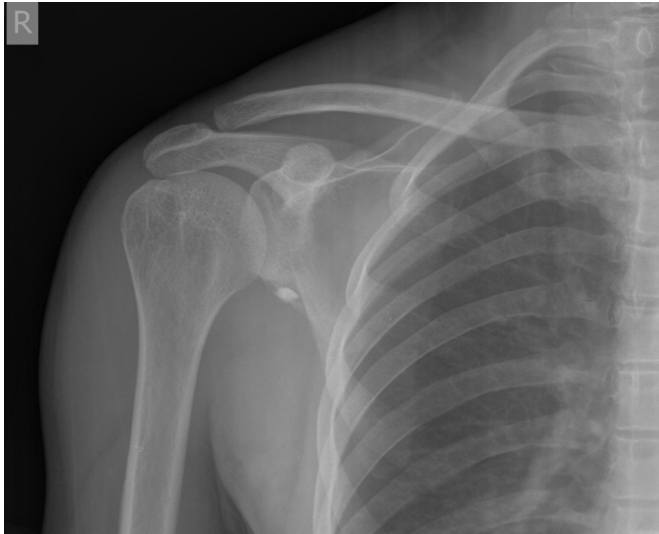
Anteroposterior radiograph of the patient's shoulders.
